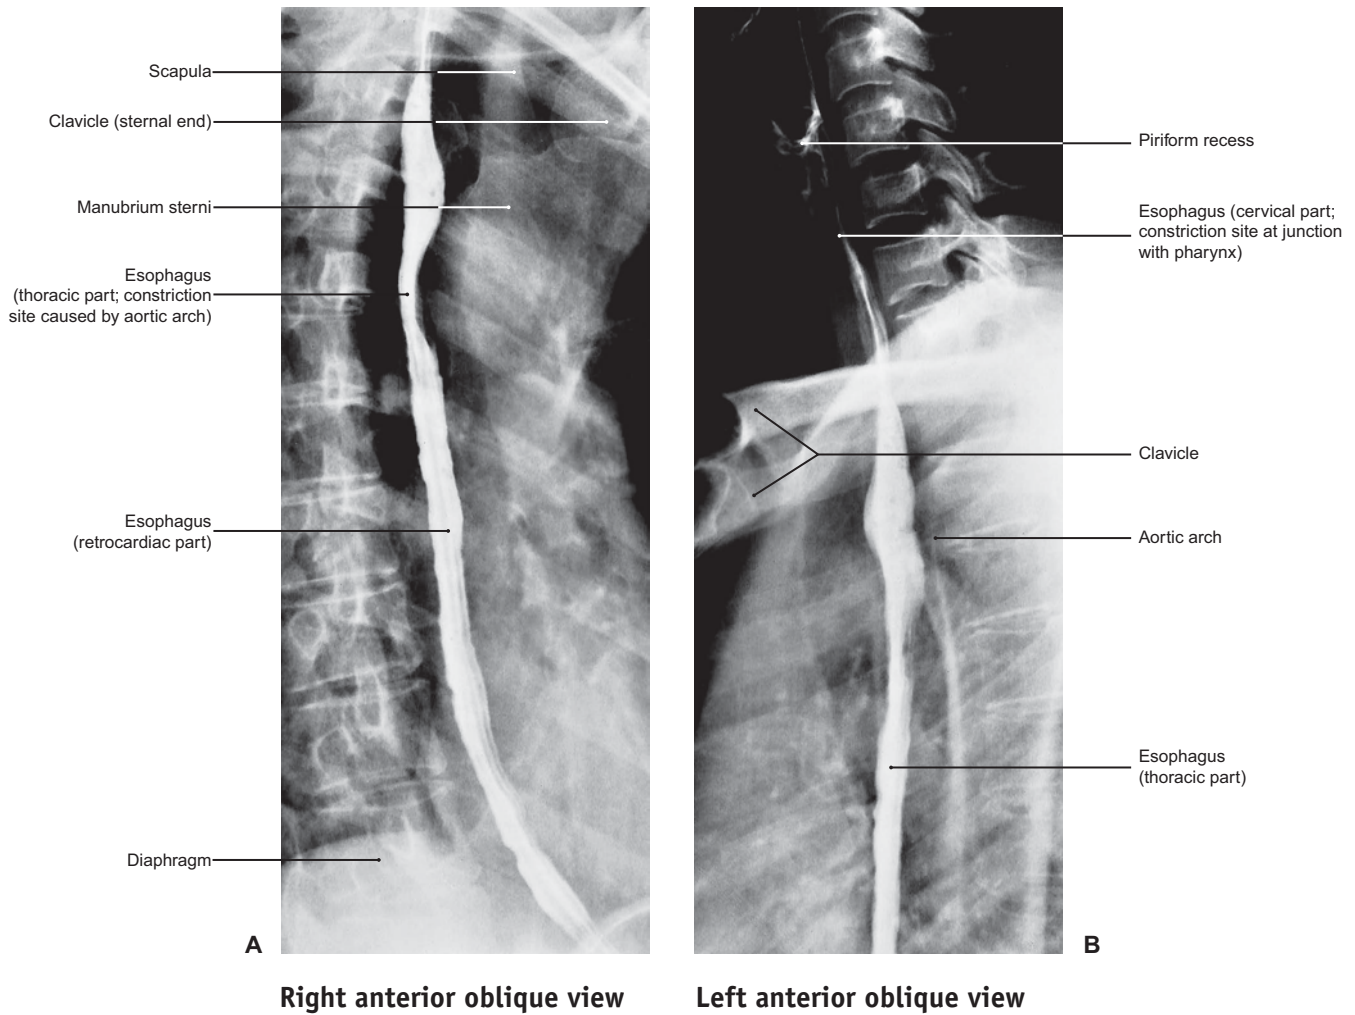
1AB Radiographic Views of the Esophagus After Swallowing Contrast Medium
